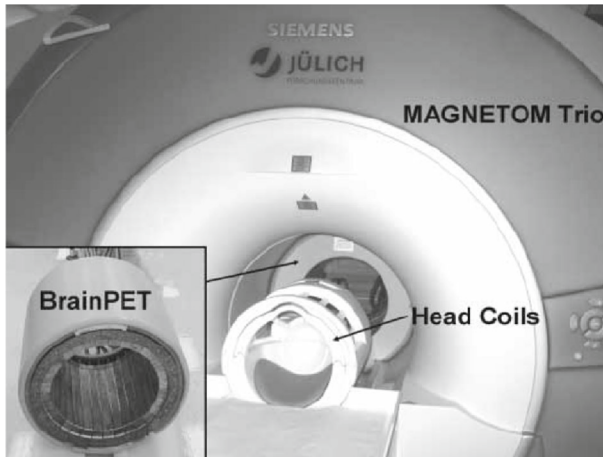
The BrainPET insert in the MAGNETOM Trio MRI and also separately with removed inner cover [179]
